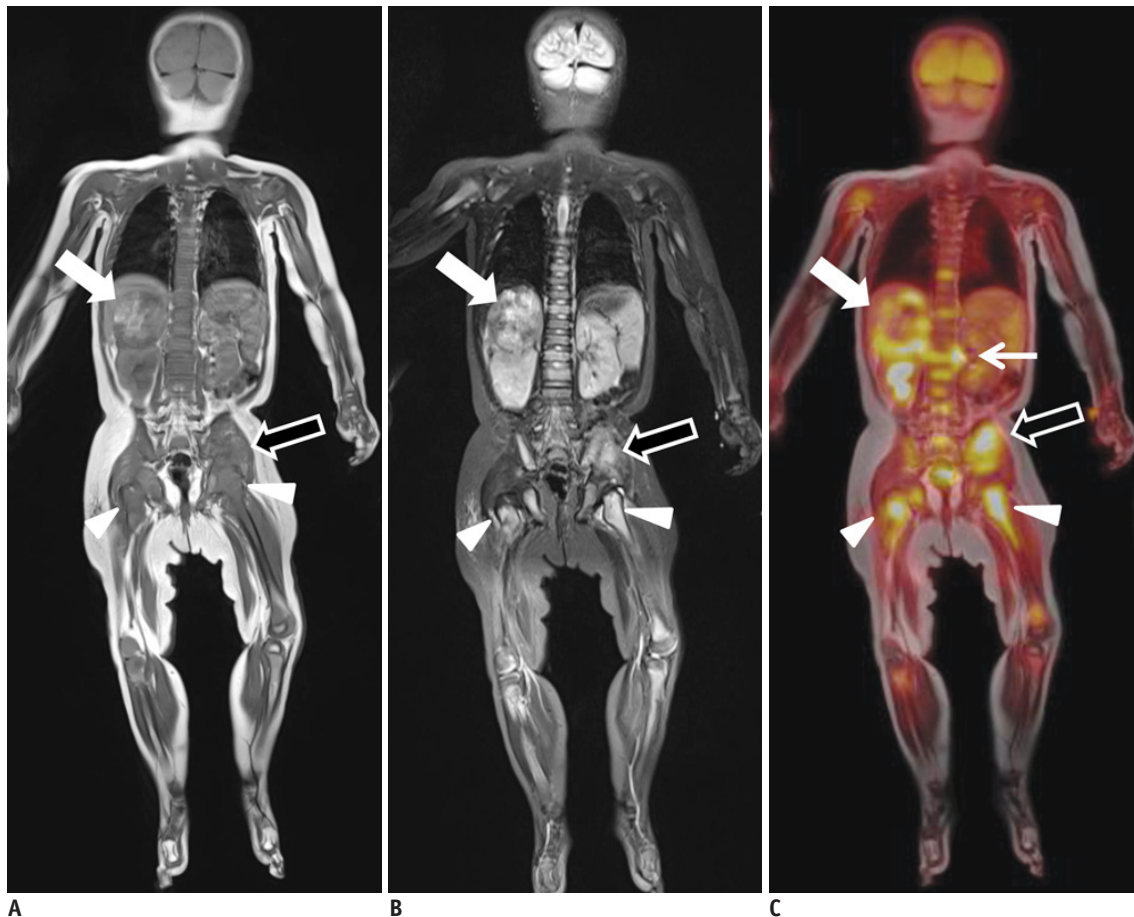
One-year-old male with neuroblastoma. Coronal, T1-weighted image (A) and coronal STIR T2-weighted sequences image (B) showed multiple, metastatic tumors in right adrenal gland (white arrow), left ilium (black arrow), and proximal metaphysis of both femora (arrowheads). C. Coronal FDG-MR/PET image demonstrated strong FDG uptake in lesions. Thin arrow shows multiple spine metastases. FDG = fluorodeoxyglucose, MR/PET = magnetic resonance imaging/positron emission tomography, STIR = short-tau inversion recovery
